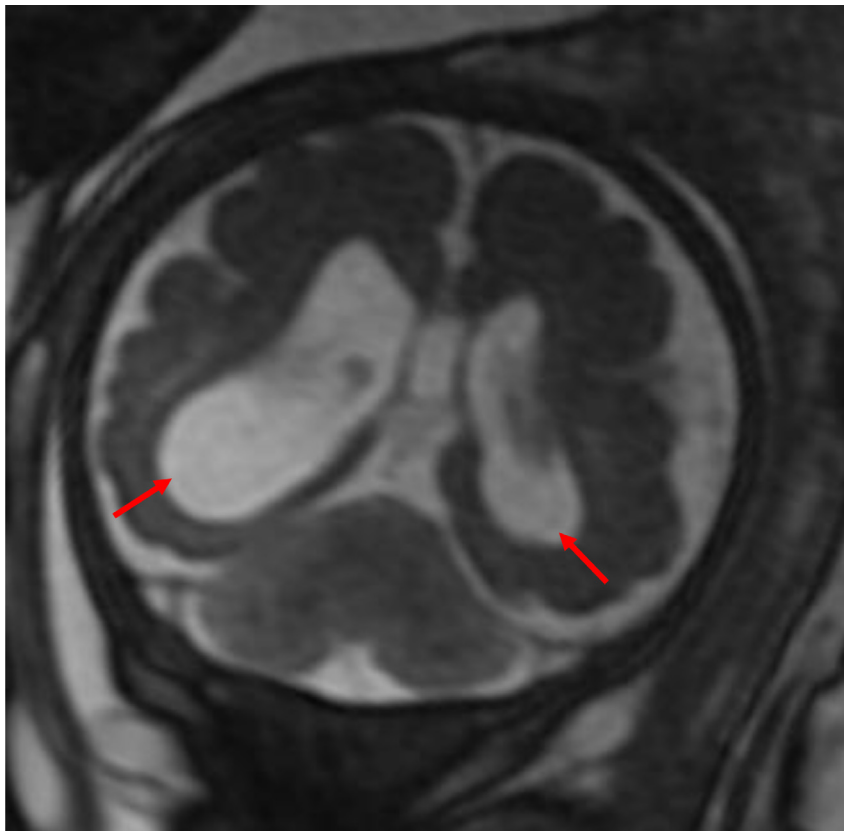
Coronal T2 FIESTA fetal MRI at 35 wk GA at the level of the bilateral ventricles confirm ventriculomegaly with asymmetric enlargement of the right greater than left ventricle (red arrow). GA, gestational age. “Color version available online.”
